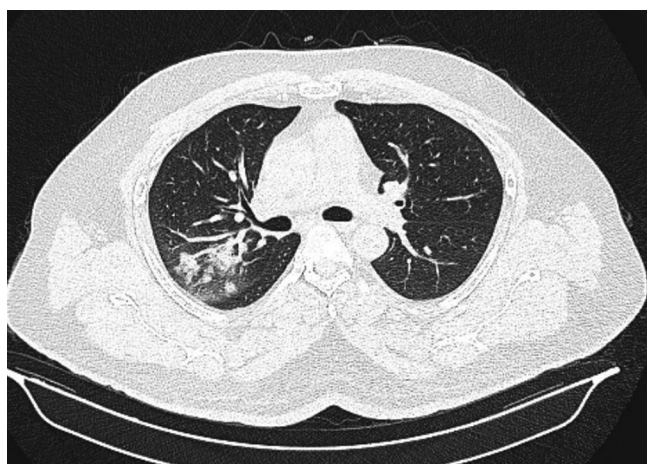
Figure/table-7: Axial HRCT chest image shows subpleural consolidation
